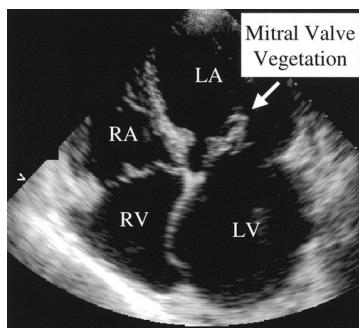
Mitral valve vegetation shown on echocardiogram
